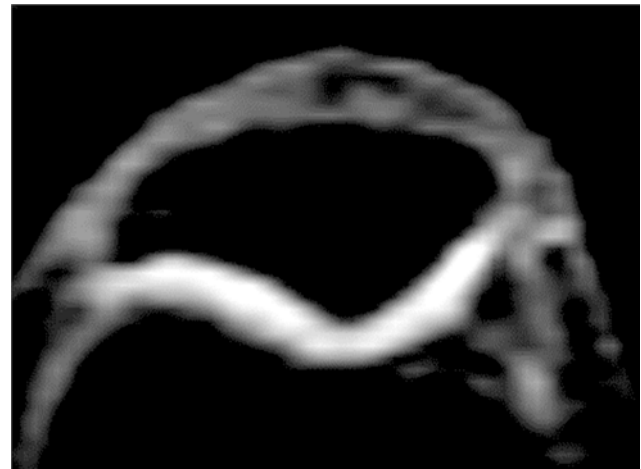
Axial slice of sodium image of a healthy human knee obtained at 4T GE MRI scanner. High sodium content in articular cartilage is reflected in the high signal compared to surrounding tissues (Reddy et al. 1998)
